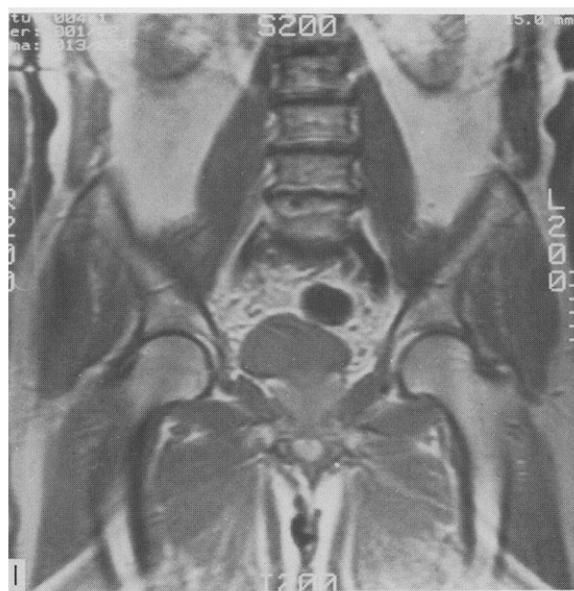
MRI appearance of normal bone marrow has high signal intensity.
